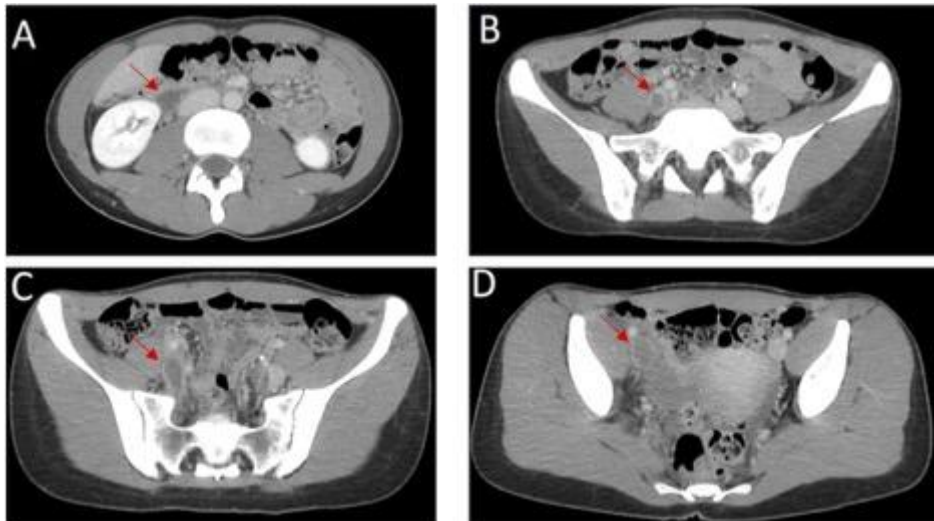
CT venogram demonstrating no thrombus in the IVC (A) occlusive thrombus within the bilateral internal iliac veins (B-C), partial occlusion of the left common iliac vein due to propagation of the internal iliac thrombus, complete occlusion of the right common iliac and external iliac veins (C-D).
